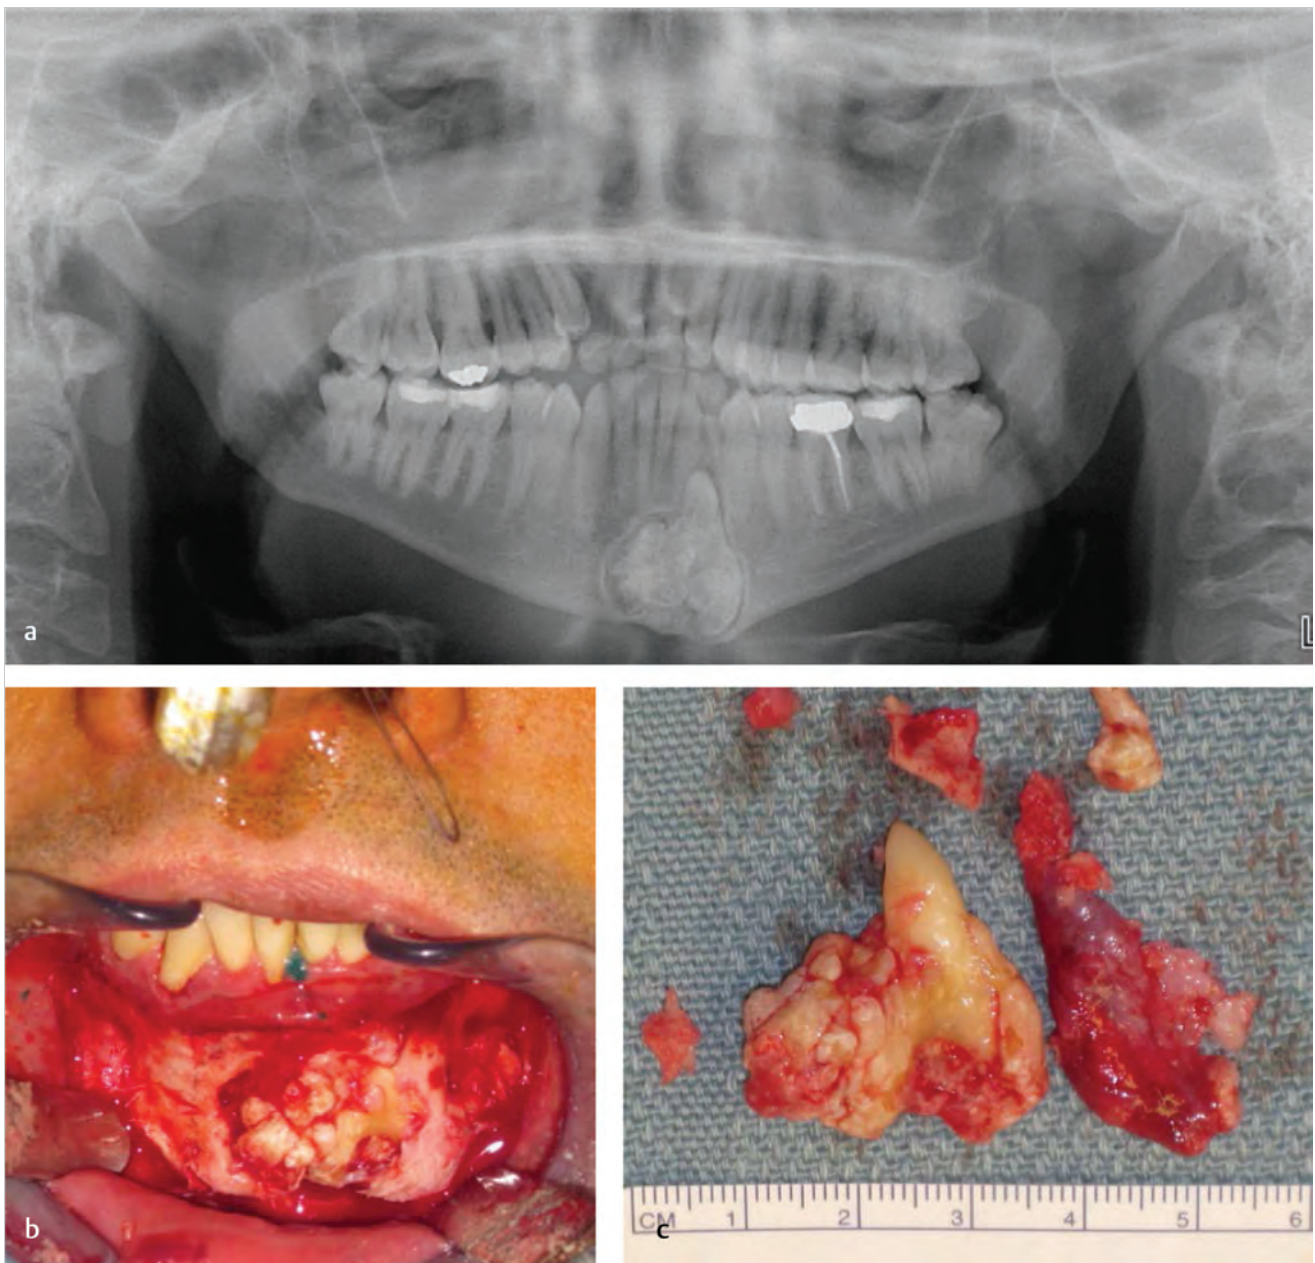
(a) Ameloblastic fibro-odontoma of the anterior mandible, radiographically similar to an odontoma. (b) Intraoperative view of ameloblastic fibro-odontoma of the anterior mandible. (c) Ameloblastic fibro-odontoma after being removed.
